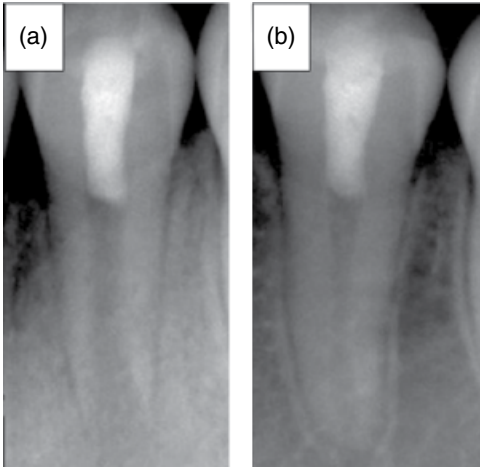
Preoperative radiograph of tooth #35 with open apex (a), and 12-month postoperative radiograph (b). Continuous root extension and canal wall thickening, relative to the preoperative image. Reproduced with permission from [110].
